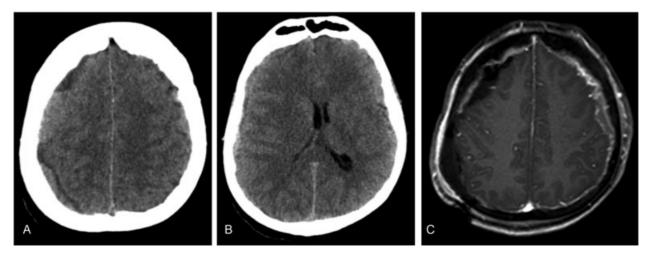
(A) Axial nonenhanced computed tomography scan of the head without contrast showing a multinodular bilateral hyperdense extra-axial lesion with (B) a midline shift of 4 mm to the right. This image was interpreted as an acute subdural hematoma. (C) Postoperative magnetic resonance imaging showed prominent irregular enhancing tissue along the dura consistent with bilateral dural metastasis.
